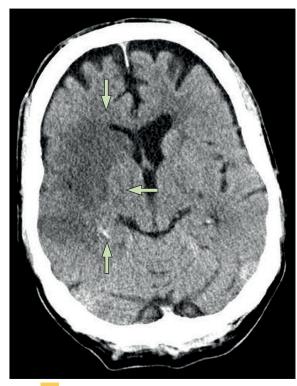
<u>Non</u>-contrast CT of a patient presenting with a right-hemispheric stroke syndrome
